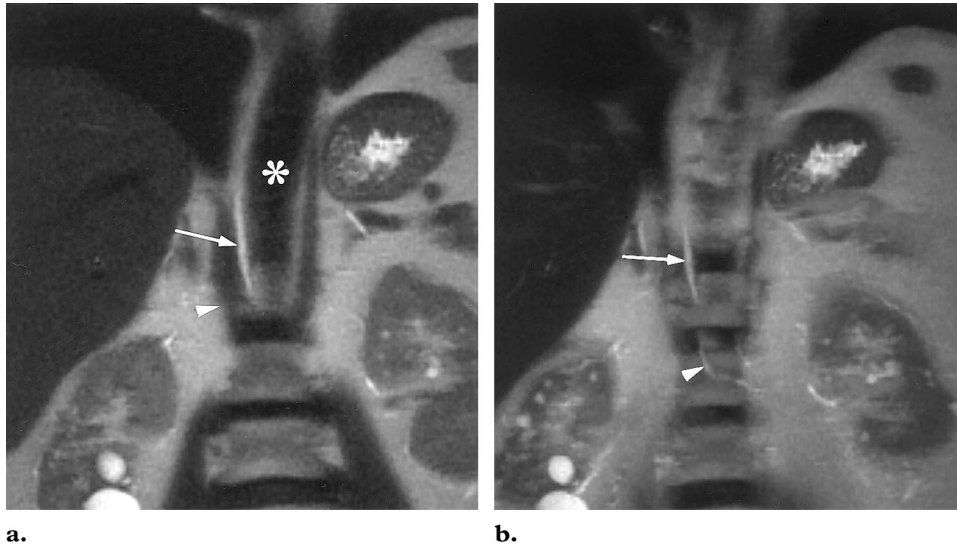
Single straight thin tube. (a) Coronal T2-weighted MR image acquired with a HASTE sequence shows a small cisterna chyli as a single straight thin tube (arrow) between the aorta (*) and the right hemidiaphragmatic crus (arrowhead). The thoracic duct is not seen. (b) MIP image, reconstructed by using several coronal sections from the same HASTE sequence, depicts the cisterna (arrow) and one of the lumbar or intestinal afferent trunks (arrowhead).
